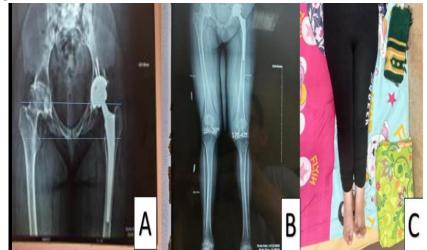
Female patient 27 years old (A) plain X-ray AP view showing right advanced OA hip and left THA. (B) Long-standing CT scanogram showing LLD of 4 cm. (C) clinical photo of preoperative LLD.
